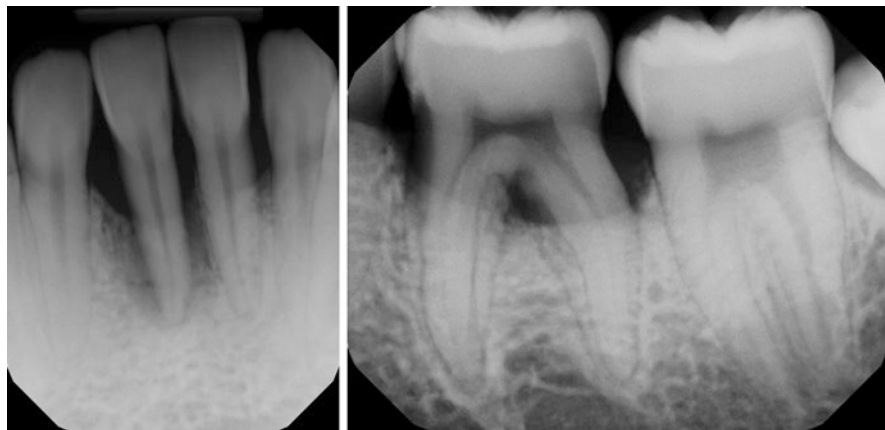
Primary periodontal lesions. Two periapical images from an 18-year-old female referred to an endodontist for evaluation. All teeth responded WNL to pulp sensibility testing. The diagnosis was localized aggressive periodontitis, and prognosis depends entirely on ability to manage periodontal disease
